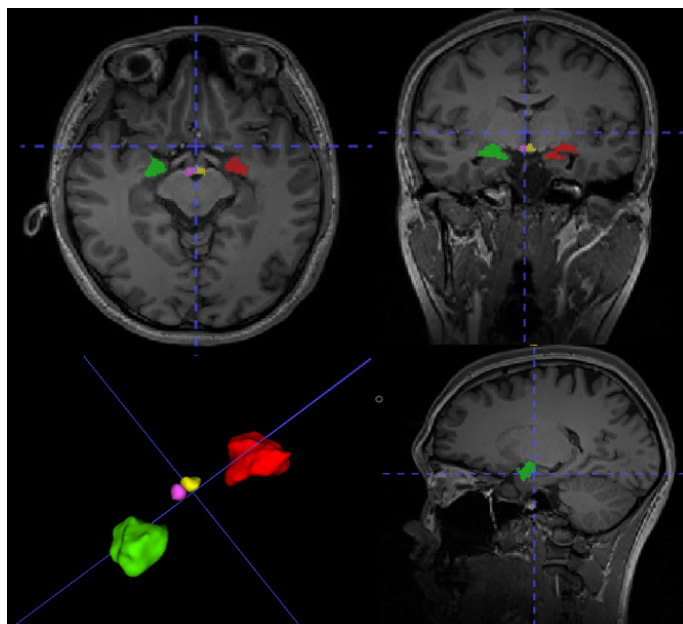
Colorization and three-dimensional modeling of MRICloud data using ITK-SNAP. Axial, coronal, and sagittal T1-weighted MR images with 3D volume renderings showing the bilateral segmentation of subcortical limbic structures using MRICloud and visualized in ITK-SNAP. Colored areas represent automatically segmented limbic structures.
